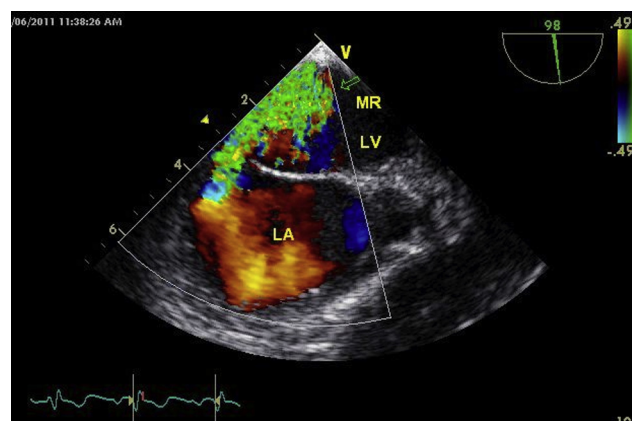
Transesophageal echocardiogram showing severe eccentric mitral regurgitation due to MV endocarditis with *Streptobacillus moniliformis*.
